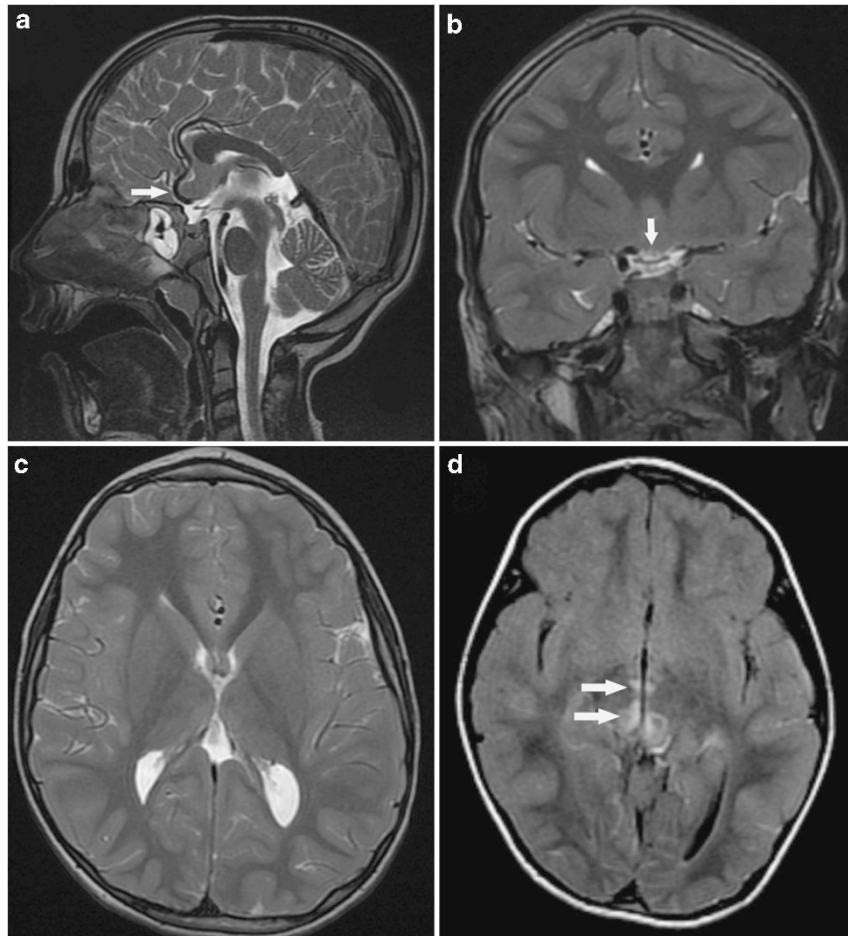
On T2 (FSE) sagittal view, (a) a short, hypoplastic corpus callosum is shown. The Rostrum is missing, and a posterior callosal hypogenesis is noted with an absence of the splenium. The optic chiasm is thin both in the sagittal (arrow head) as well as in the coronal (b) view indicating optic atrophy. Note the absence of the splenium on the T2WI axial view (c). There are bilateral high intensity foci (arrows) in the mesencephalon and the Thalamus, shown on T2 FLAIR image (d) with restricted diffusion, typical for mitochondrial disorders.
